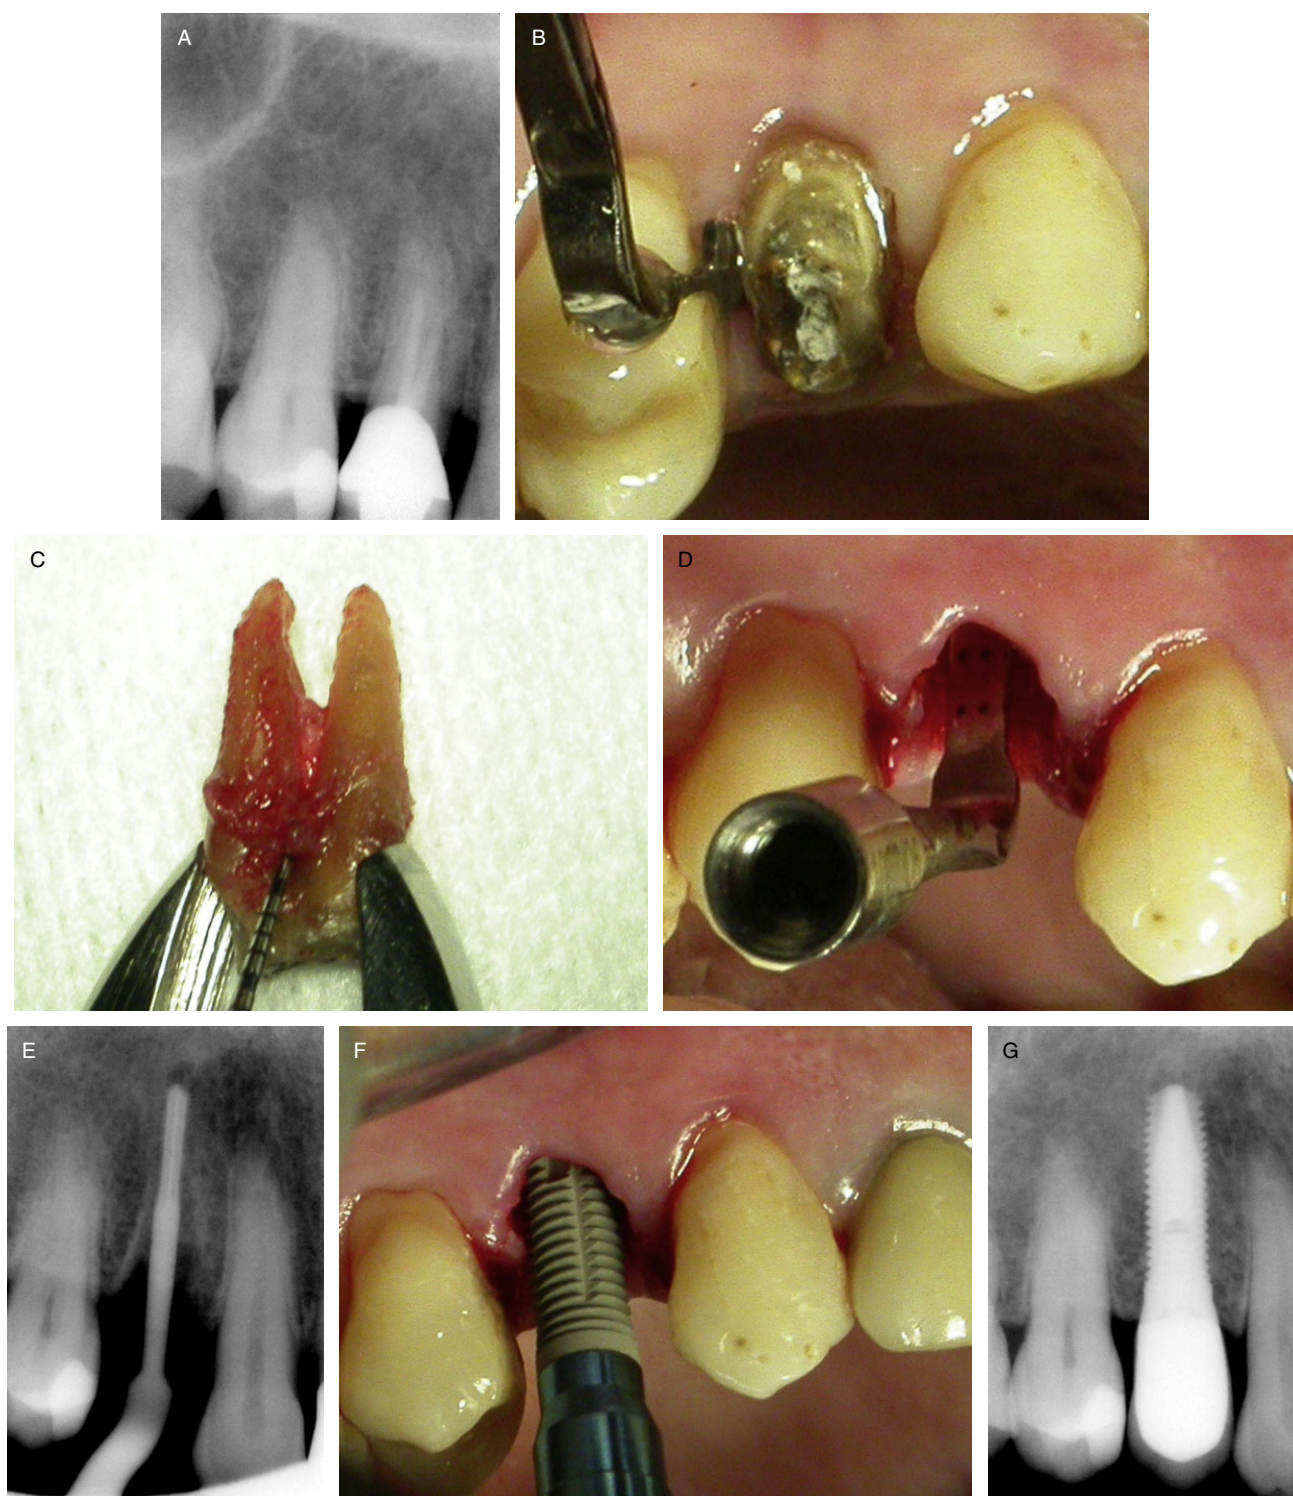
Treatment of a chronically infected site with an immediate implant. *A*, Radiograph of the infected tooth to be extracted. *B*, Cutting the periodontal ligament (PDL) fibers with the arrow-like tip on the distal side of the tooth. *C*, Chronically infected tooth after extraction. *D*, Vibrating tip placed in the osteotomy showing direction of the implant to be placed. *E*, Radiograph of the vibrating tip during preparation of the osteotomy. *F*, Immediate implant placed. *G*, Radiograph at the 2-year control.
